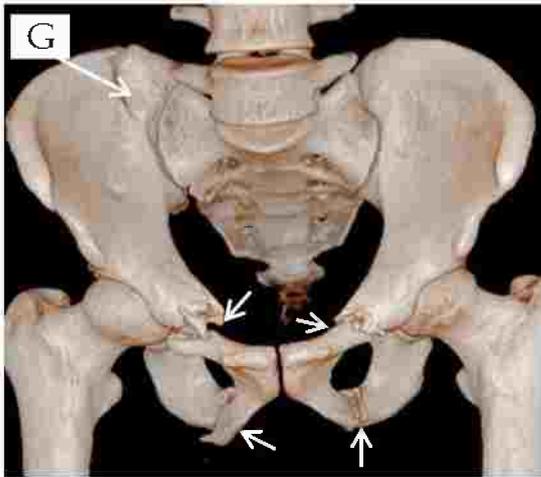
23 years old male with history of road traffic accident, (A, B, C, D) axial CT, (E, F) coronal CT bone windows and (G,H) VR images (anterior view in H and posterior oblique view in G) they are showing right iliac bone fracture reaches to the right SI joint (long arrow in A,G,H), the right SI joint diastasis in both anterior and posterior with (short arrows in B). Both right and left superior and inferior pubic rami are fractured (short arrows in D, E,G,H), with fragment (Green arrow in C).
